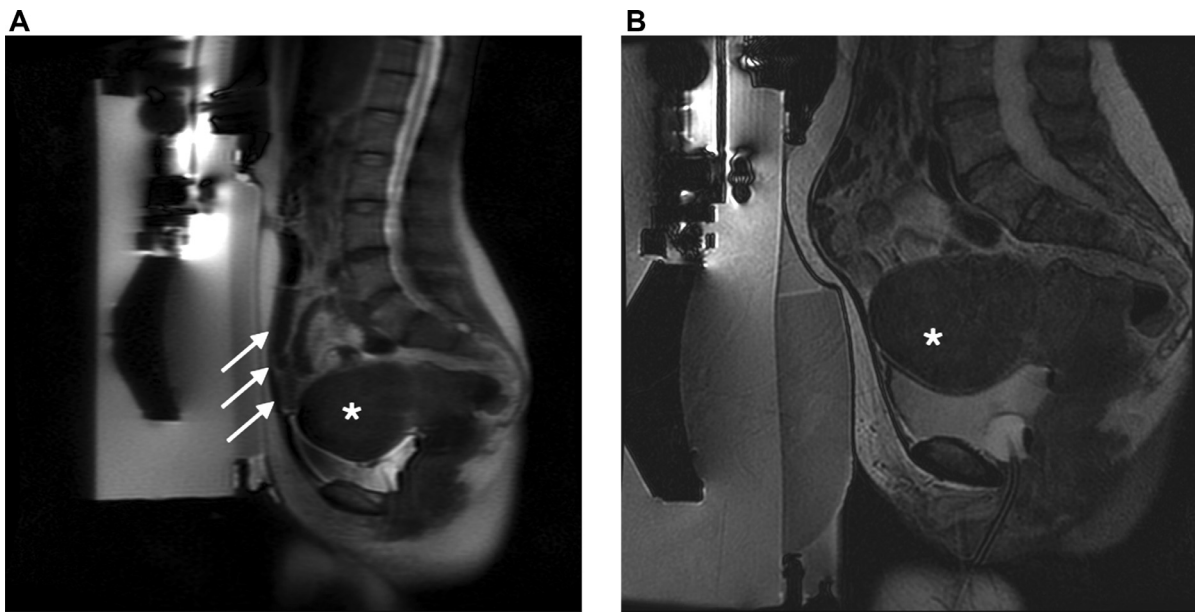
(A) MR images of a patient with a uterine subserosal myoma with a maximum diameter of about 95 cm (white star in A and B). The scout sagittal MR image shows the bowel interposition between the transducer and the fibroid (white arrows). (B) Bladder filling with the US gel shows displacement of the uterus and the bowel loops, as shown in the T2-weighted MR image.
